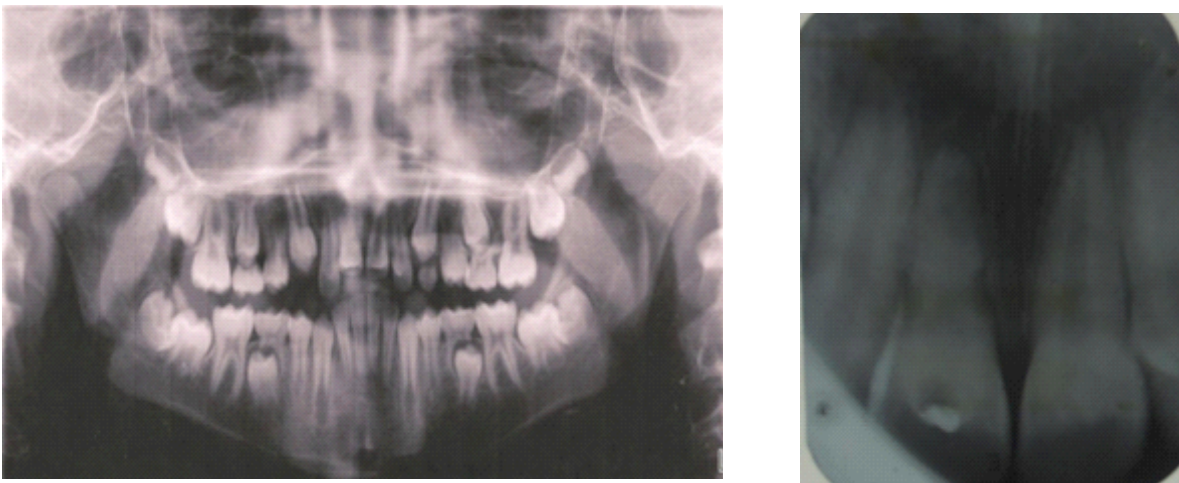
Pretreatment dental panoramic and periapical radiograph
